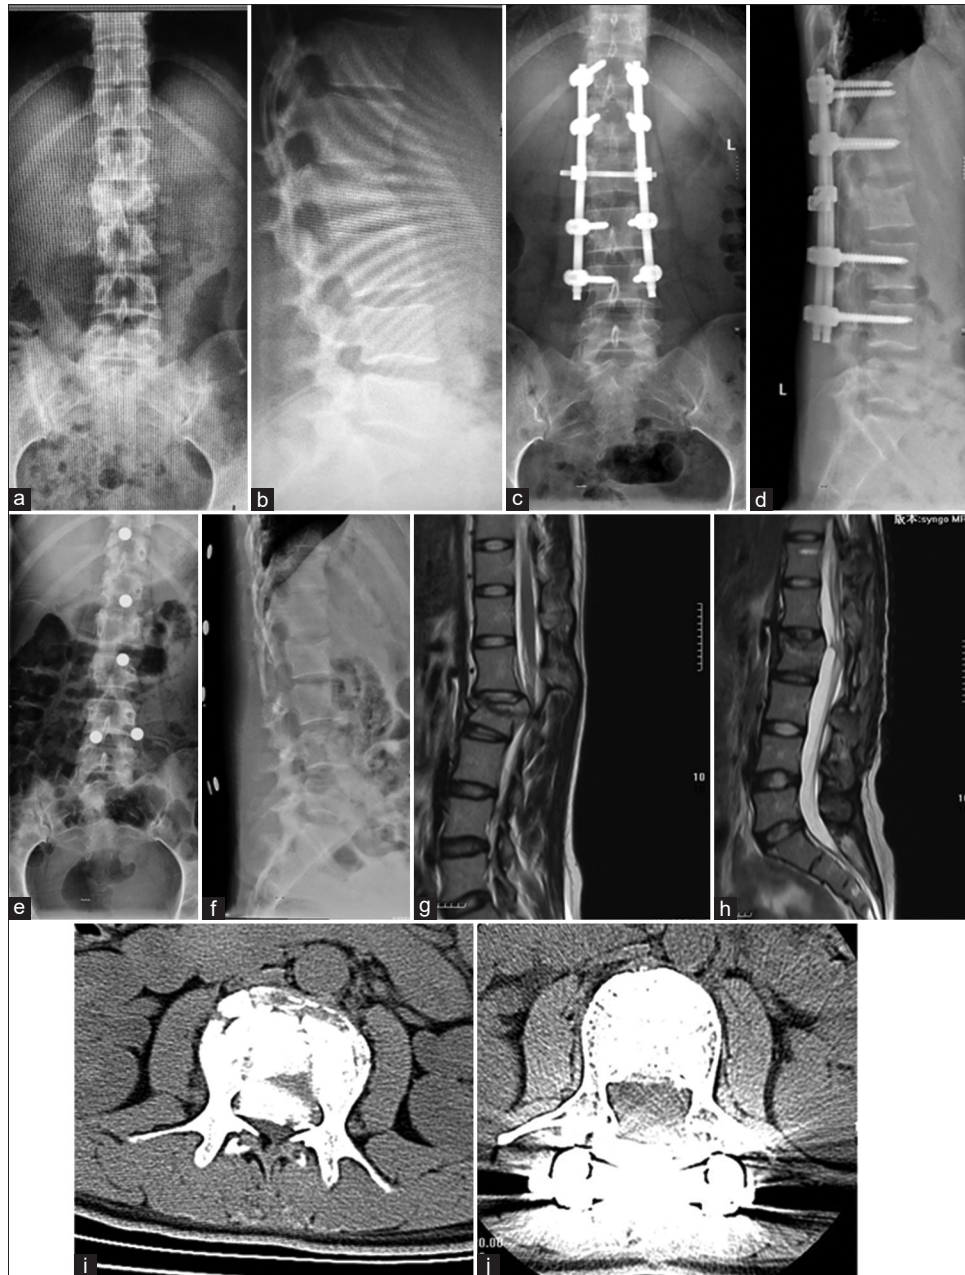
A 20-year-old female patient was injured by falling from a high place, with L2 vertebral fracture and incomplete paralysis. (a and b) Preoperative X-ray showed fracture of L2 vertebral body and kyphosis deformity, (c and d) Postoperative X-ray showed that the height of L2 vertebral body was well reduced without kyphosis, (e and f) The internal fixation was removed 1 year after operation, and the X-ray showed that the height of L2 vertebral body was good and there was no kyphosis, (g) Preoperative magnetic resonance imaging (MRI) showed compression fracture of L2 vertebral body, protruding to the spinal canal and compressing the spinal cord, (h) One year after the operation, the internal fixation was removed and the MRI showed that the height of L2 vertebral body was acceptable and the spinal canal was not narrowed, (i) Preoperative computed tomography (CT) showed burst fracture of L2 vertebral body. The fracture fragment protruded to the spinal canal and compressed the spinal cord. The degree of spinal canal stenosis was 80%, (j) Six months after operation, CT showed that the fusion of the reconstructed iliac lamina was good and the spinal canal was not narrowed
